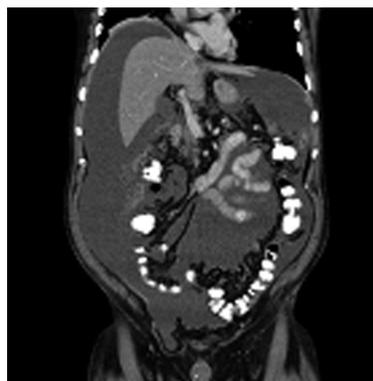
Abdominal computed tomography scan at the first presentation demonstrating voluminous ascites throughout the abdominal cavity.
